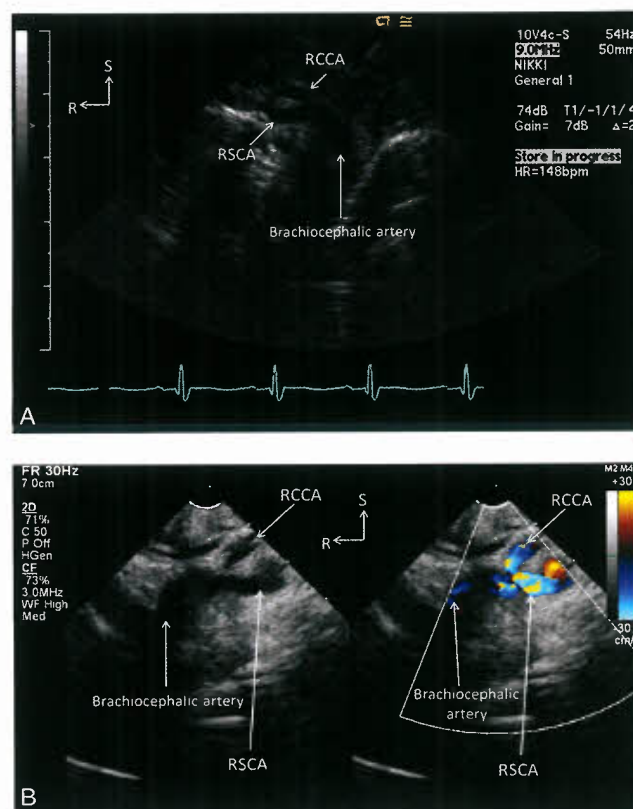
Suprasternal notch short-axis views in a patient with left aortic arch (A) and a second patient with right aortic arch (B). In each view, the transducer is swept superiorly to demonstrate the bifurcation of the brachiocephalic artery. In the patient with a left aortic arch, the first strap vessel arising from the aortic arch is the brachiocephalic artery which bifurcates toward the right into right subclavian (RSCA) and right common carotid arteries (RCCA), indicating a left aortic arch. In the second patient with a right aortic arch (B), the first strap vessel is a left brachiocephalic artery, and it bifurcates to the left into the left subclavian (LSCA) and left common carotid (LCCA) arteries, indicating a right aortic arch. Color Doppler can be helpful in tracking these arteries distally to determine their branching patterns as shown by the color Doppler panel in B. R, right; S, superior.
